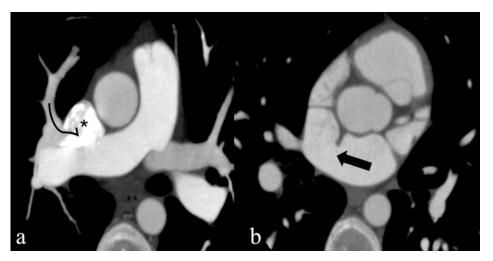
(a) Right superior pulmonary vein (arrow) drains into the vena cava superior (star). (b) Axial CT image shows the sinus venosus type atrial septal defect (black arrow)
